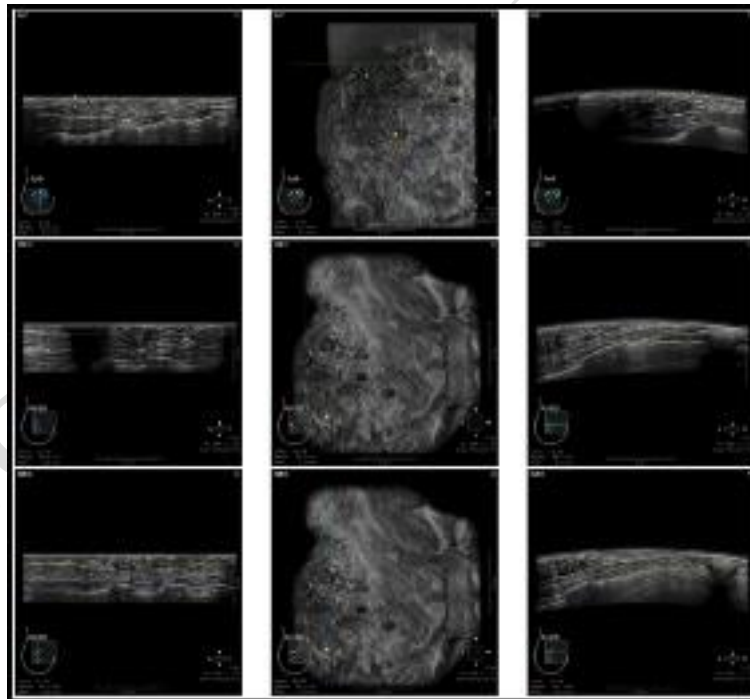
A 3-dimensional Ultrasonography Showed Multiple Hypoechoic Lesions with Sharp Demarcation at the Follow-up Appointment.
